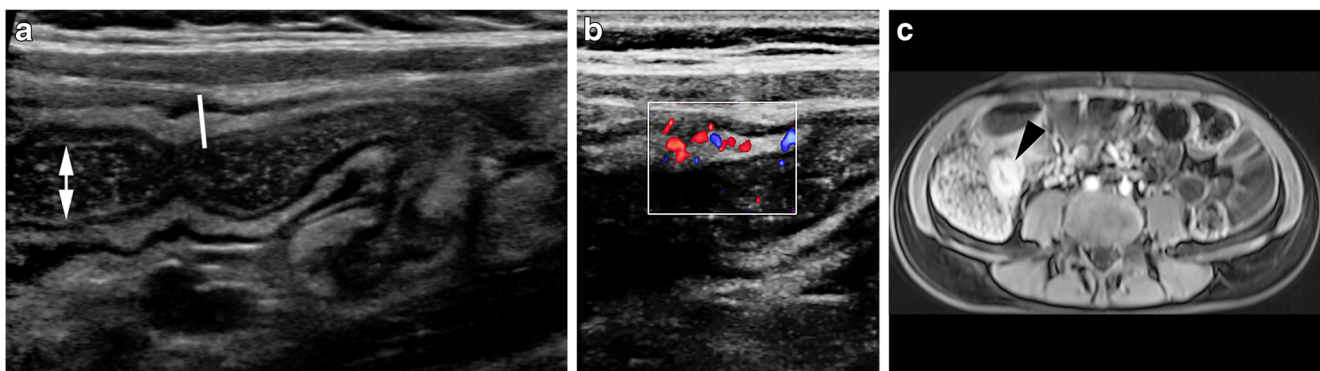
A diagnosis of terminal ileitis by ultrasound in a 16-year-old girl with Crohn disease. Long-view gray-scale US shows the thickened terminal ileum (a), wall thickness (white line) and lumen (double-headed arrow) with marked increased vascularity on color Doppler (b).
